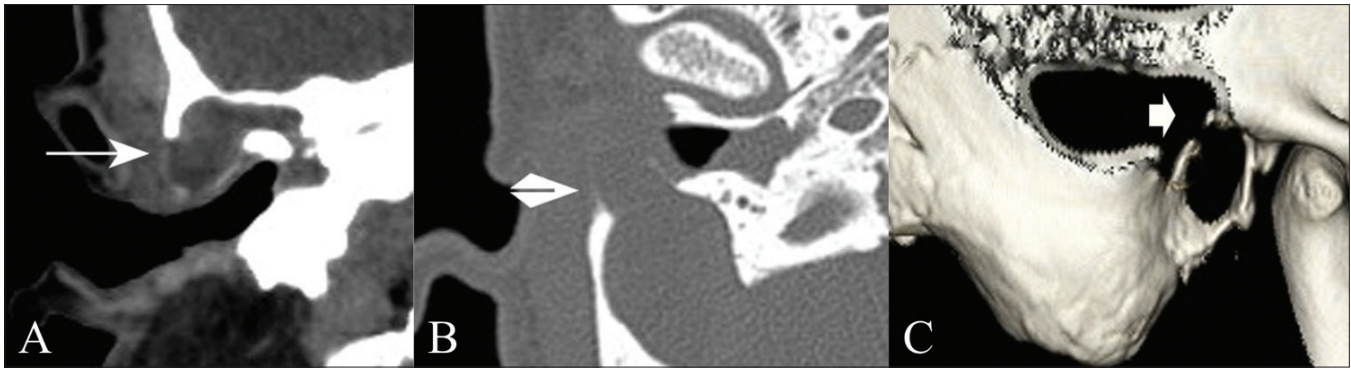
(A-C): Cholesteatoma of the EAC: noncontrast coronal CT scan (A) and axial HRCT image (B) show a hypodense lesion in the right EAC (arrow in A and arrowhead in B) invading the mastoid (stage III). 3D volume rendered image (C) shows a small, post-biopsy defect in the mastoid wall
